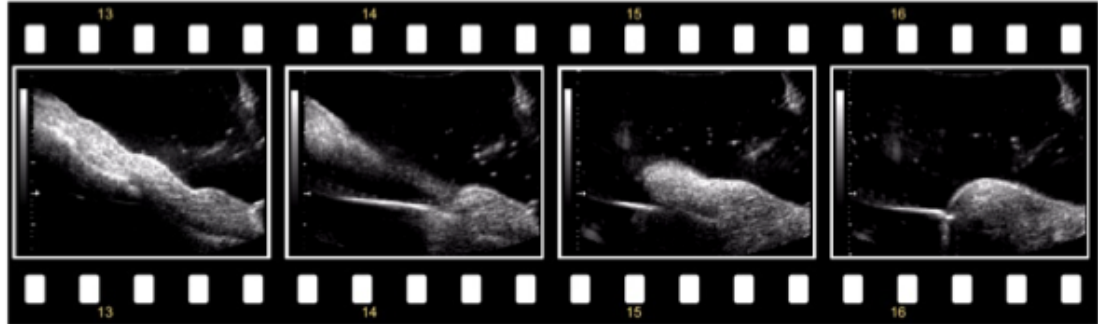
Ultrasound consecutive frames saved in AVI format, depicted in film frame arrangement.
